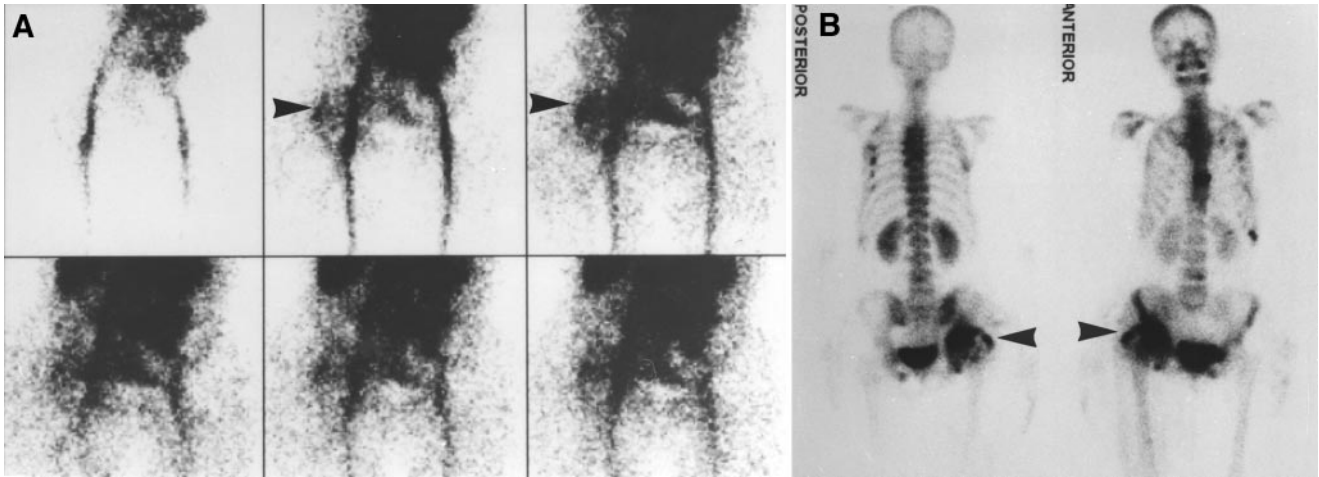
Fever, leukocytosis, and elevated alkaline phosphatase developed in 64-y-old woman 2 mo after trauma that had caused fractures of spine, rib, sternum, right knee, and right hip and pelvis. Right acetabular fracture had been repaired surgically immediately after trauma. (A) Flow study shows increased perfusion projecting over soft tissues just lateral to right hip (arrowheads). (B) Delayed bone scan shows increased uptake at same site (arrowheads) and at multiple healing fracture sites. Retrospective review of serial right hip radiographs confirmed presence of HO in soft tissue lateral to right hip joint. Patient recovered, and no other cause for fever was found.
